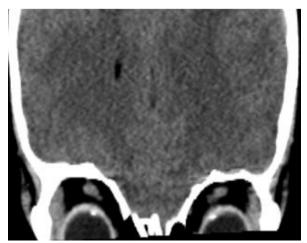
Figure A non-contrast coronal view CT brain
